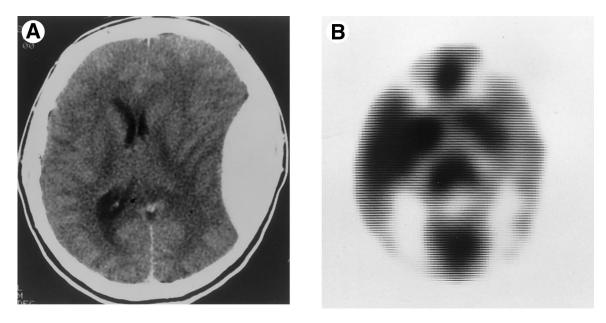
(A) CT image of a patient with head trauma who sustained a left sided epidural hematoma. (B) The corresponding FDG PET scan shows hypometabolism in the left hemisphere extending beyond the area directly affected by the hematoma and including the temporal and parietal cortices. (Reprinted with permission from Newberg A, Alavi A: Neuroimaging in patients with head trauma, Nucl Med Ann, 1996, pp 195-212).
